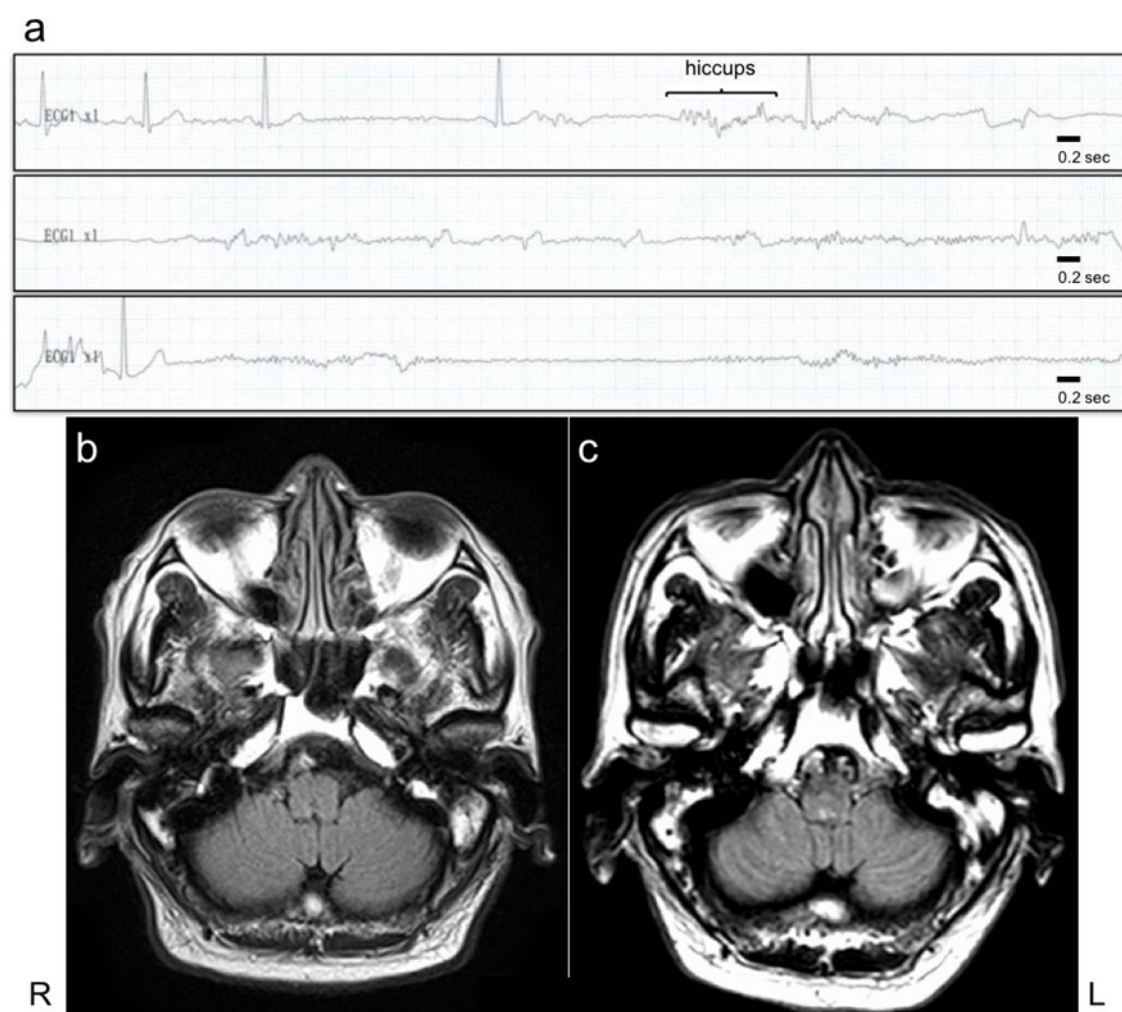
Sick sinus syndrome was subsequent to persistent hiccups (a). FLAIR imaging on admission did not show any hyperintensities in the area postrema (b), but it became prominent 13 days following admission (c).
